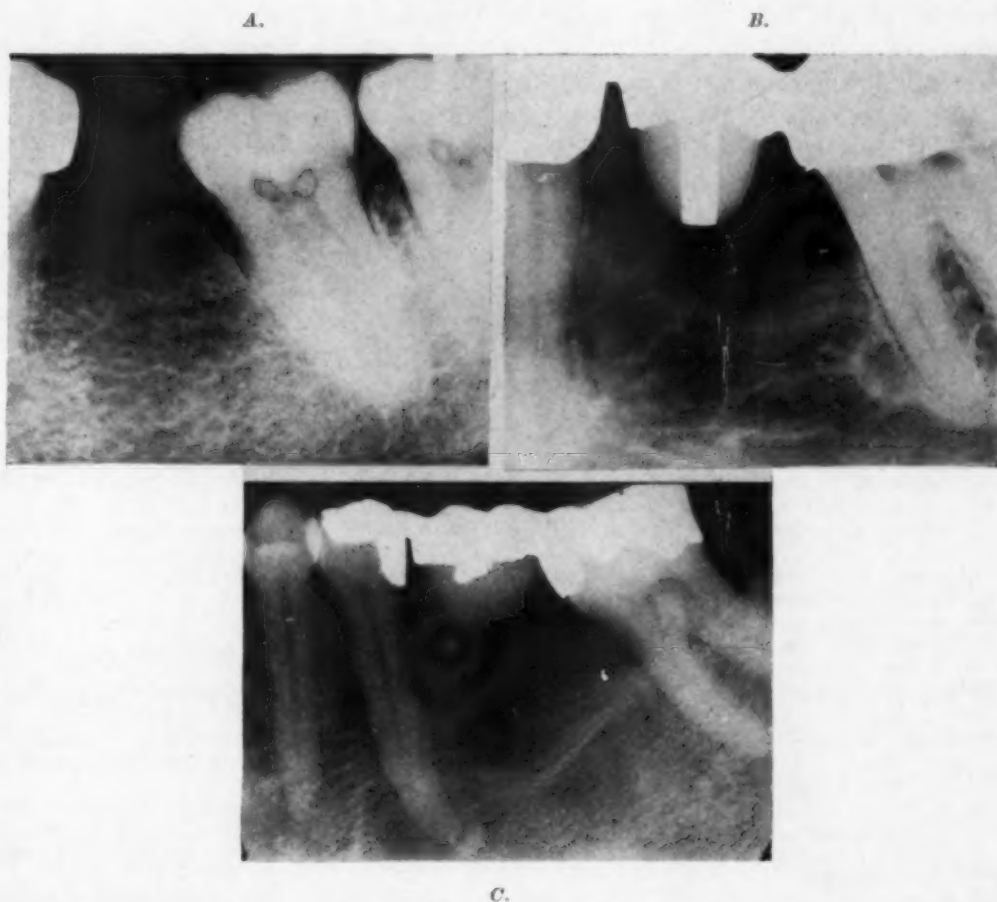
Roentgenographic reproductions of lower left first molar areas. *A*, Normal bone structure; *B*, progressive bone atrophy; *C*, osteodystrophy (Paget's disease). (Pl. 998, 1030, 1161.)
